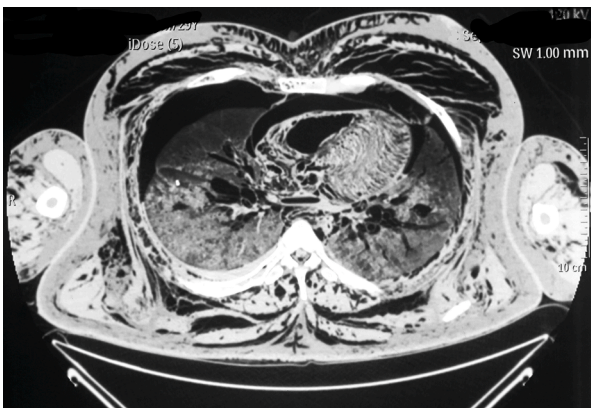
CT Lung Axial view: Bilateral pulmonary diffuse ground-glass opacities along with right-sided minimal pleural fluid, more on the dependent aspects.
